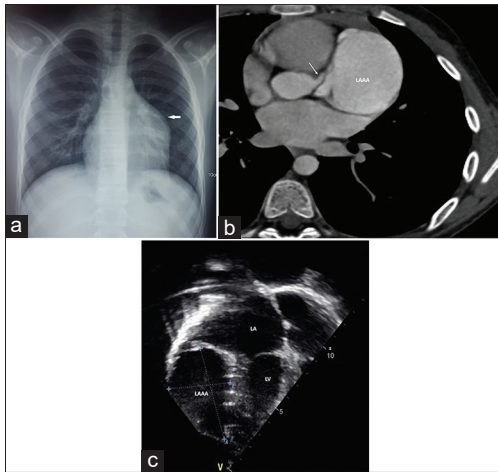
(a) Chest X-ray demonstrating prominent upper left heart border. (b) Transthoracic echocardiogram showing an apical four chamber. The left atrial appendage aneurysm is communicating with the left atrium. (c) Coronary computed tomography angiography demonstrating a distinct separation between the mass (arrow) and the left main coronary artery (arrow)
